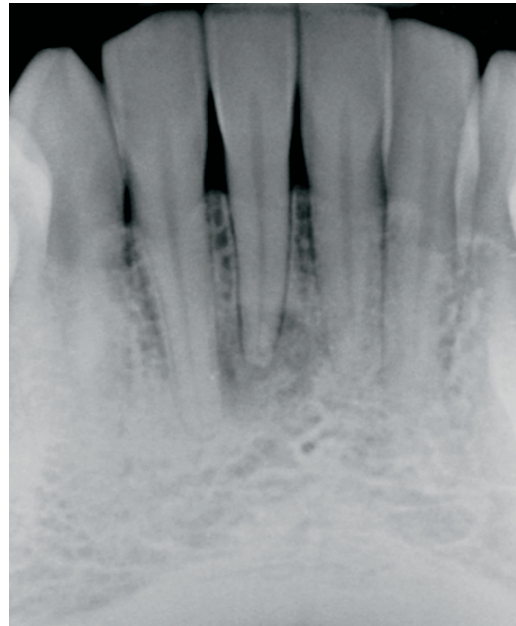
Periapical radiograph showing circumscribed periapical radiolucency with central opacities involving tooth #25.
